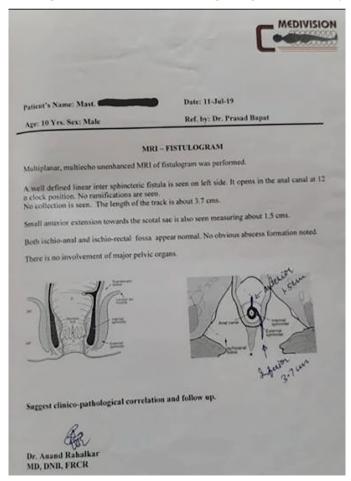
Magnetic resonance imaging fistulogram
